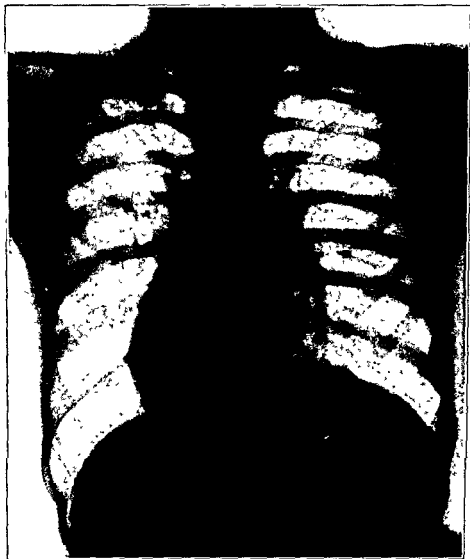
Further extension of the disease with no symptoms and physical findings. Eight months have elapsed since the taking of the x-ray in Fig. 65.
